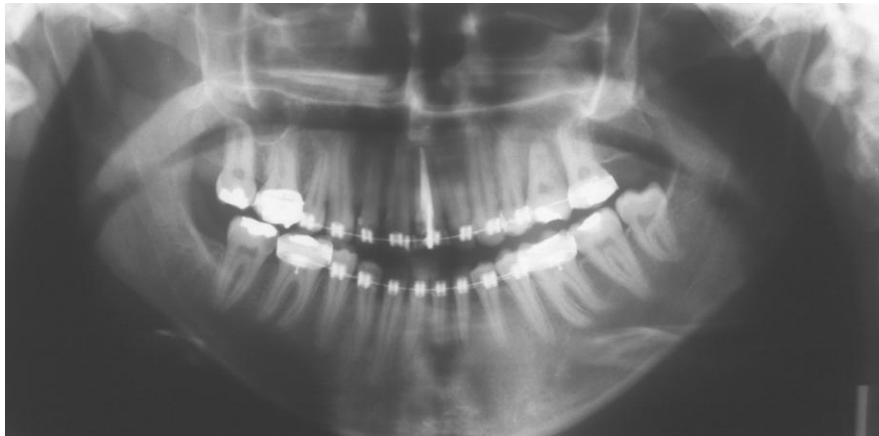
Panoramic radiograph after autotransplantation.
